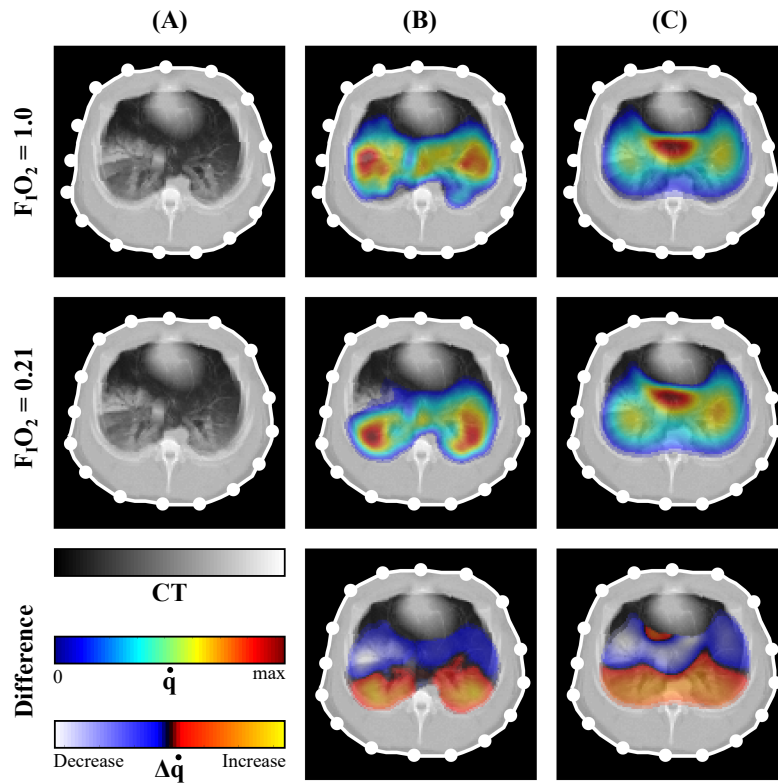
Regional blood flow distribution for two different F_1O_2 . Grayscale CT images (A) are depicted together with computed CT blood flow $\dot{q}_{CT,PCB}$ (B) and computed EIT blood flow \dot{q}_{EIT} (C) for $F_1O_2=0.21$ in the injured lung (upper row) for $F_1O_2=1.0$ in the injured lung (middle row). The spatial increases and decreases in perfusion ($\Delta\dot{q}_{CT,PCB}$ and $\Delta\dot{q}_{EIT}$) from a $F_1O_2=0.21$ to a $F_1O_2=1.0$ are depicted in the last row. The images have been taken from our publication with permission [142].
